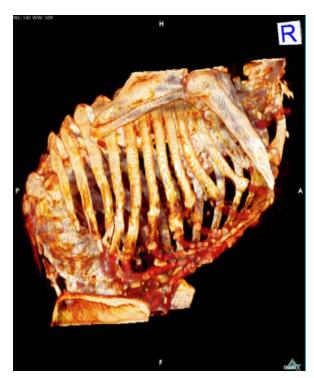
87-year-old woman with chest pain following a fall, 3-dimensional CT scan reconstruction showing thoracic cage deformity, kyphoscoliosos, and displaced manubrial fracture.
